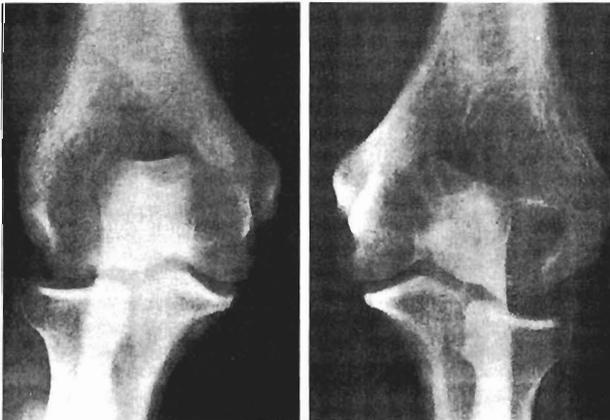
Radiograph of an 8-week-old fracture previously treated by closed reduction. Because there is malunion, an open reduction and pinning were carried out, and postoperatively a transient ulnar nerve palsy was noted. Eight years later, the elbow is pain-free but lacks 35-degree extension and 30-degree pronation, and the radial head shows posterior subluxation. The enlarged radial head and capitellum are due to prolonged hyperemia.
